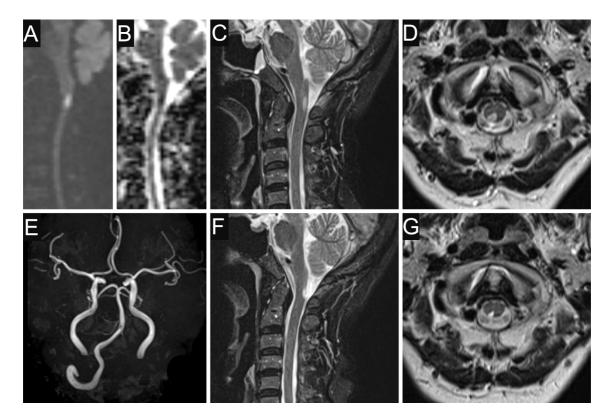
Magnetic resonance imaging of the brain and cervical spinal cord. (A) Sagittal diffusionweighted imaging showing a hyperintense lesion at the C2 spinal cord level. (B) A sagittal apparent diffusion coefficient map showing a hypointense lesion at the spinal cord level C2. (C) Sagittal T2weighted imaging of the cervical spine showing a hyperintense lesion in the posterior part of the C2 spinal cord. (D) Axial T2-weighted imaging shows a hyperintense lesion in the right posterior column and dorsal root entry zone at the C2 spinal cord level. (E) Magnetic resonance angiography showing hypoplasia of the left vertebral artery. (F) On three-month follow-up T2-weighted imaging, the size of the T2 hyperintense lesion had decreased. (G) In the axial slice, T2 hyperintensity was strictly localized to the right posterior column.
